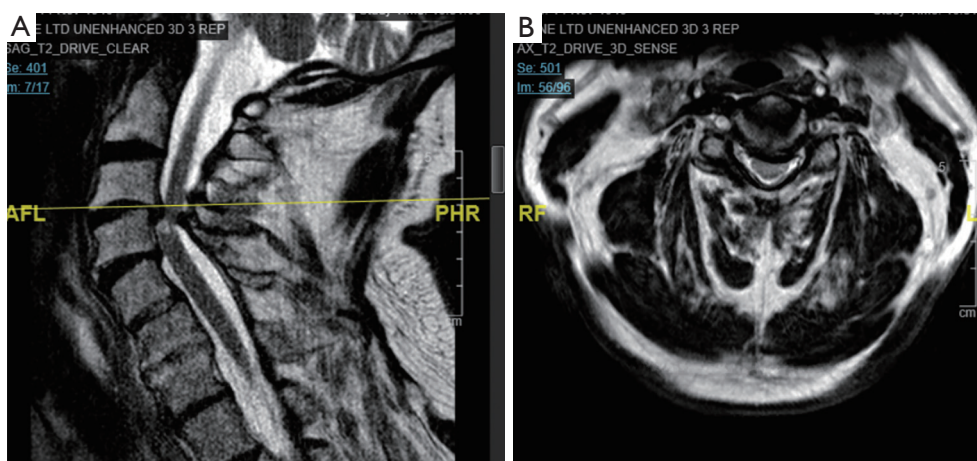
Sagittal T2 MRI (left), and axial T2 MRI (right) of the index level, showing the spinal stenosis and spinal cord myelomalacia.
